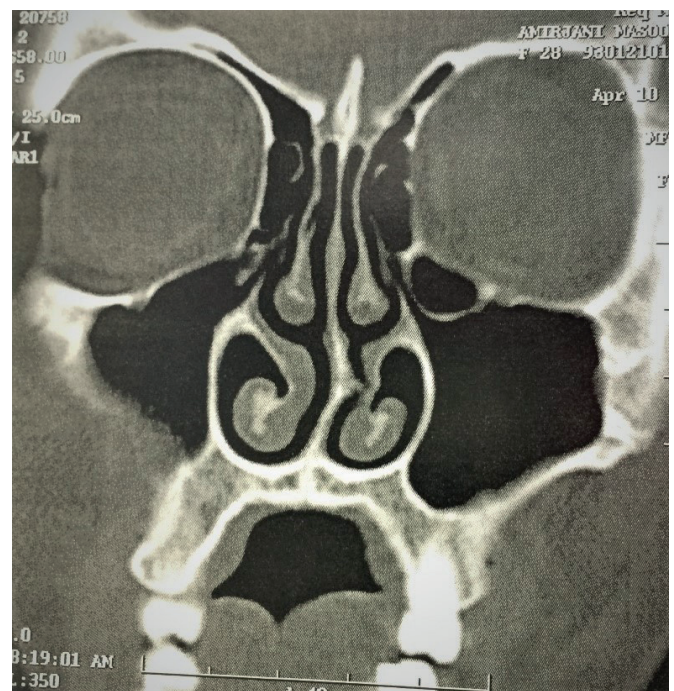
A coronal CT image of a Haller cell
